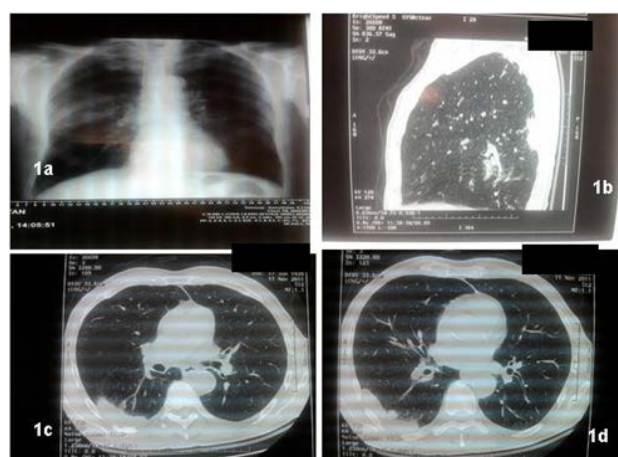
1a: Postero-anterior chest radiography performed on November 8, 2011 shows flattening of both hemidiaphragms and nonhomogenous triangle opacity, with ill defined margins localized in middle area of right hemithorax; 1b,c,d: Axial computed tomography (CT) scan of the chest performed on November 11, 2011 reveals mediastinal lymphadenopathy, pulmonary emphysema, apical and posterior right pleural thickening and a peripheral invasive solid lung tumour > 8mm in greatest dimension (25/86/64 mm) with chest wall involvement and bone destruction (right 7th rib). Lung mass appears homogenous with spiculated margins, in the right upper lobe and Fowler segment of the right lower lobe which invades chest wall.
